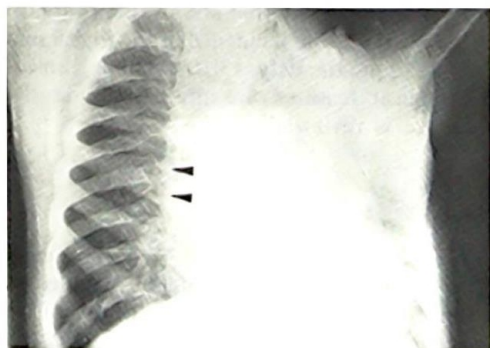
Right anterior oblique chest radiograph of same patient as in Fig 1 showing anterior portion of expanded rib before bifurcation.
